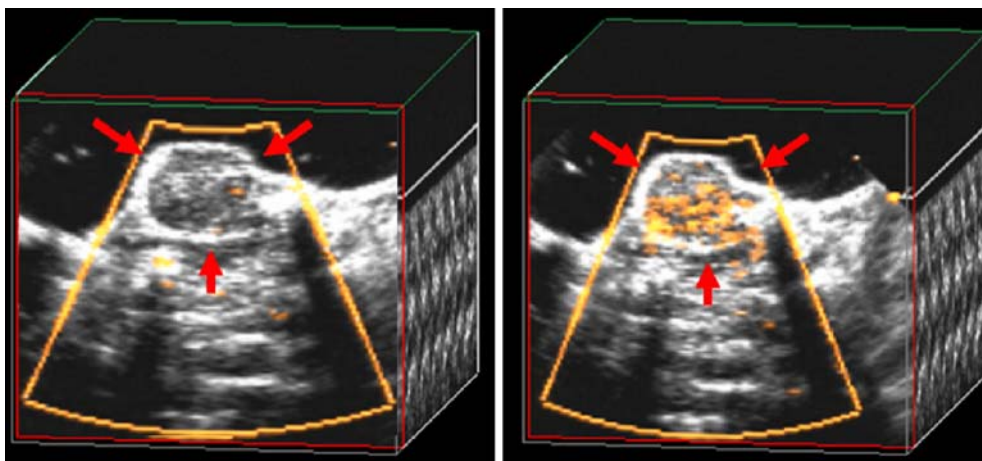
Molecular ultrasound imaging using microbubbles targeted to vascular endothelial growth factor receptor-2 (VEGFR-2).
